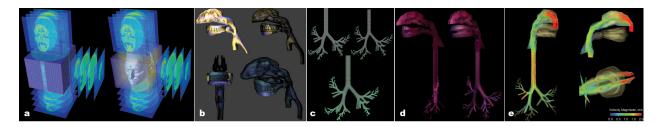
A volumetric data set created from combining a series of MRI images. The image shows how a surface is created by extracting a particular threshold value, called an *isosurface*, from the volume data (a). Extrathoracic airways combined with the oral cavity (b). Bifurcation model combines the pharynx showing one complete 23 generation path in each of five lobes (c). Complete contiguous typical path model, including nasal and oral cavities (d). Traces of the velocity magnitude (cm/s) are shown for an inhalation laminar flow study (e).
